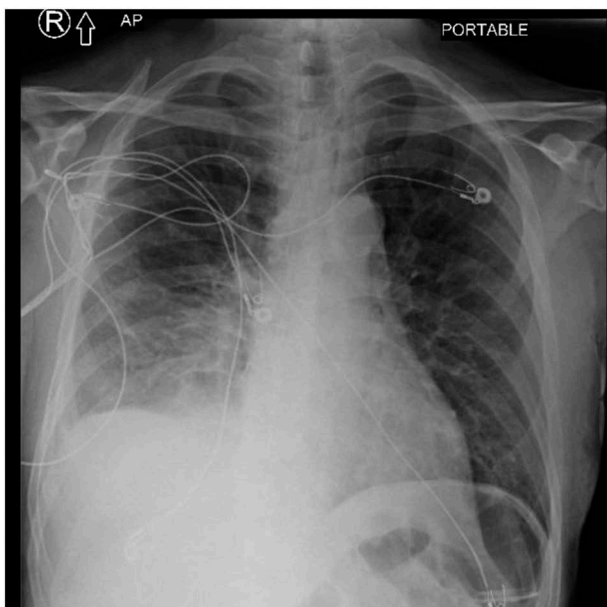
Chest x-ray shows moderate right effusion, hazy opacities at the right lung base and vague ground glass changes in the left lung base.
